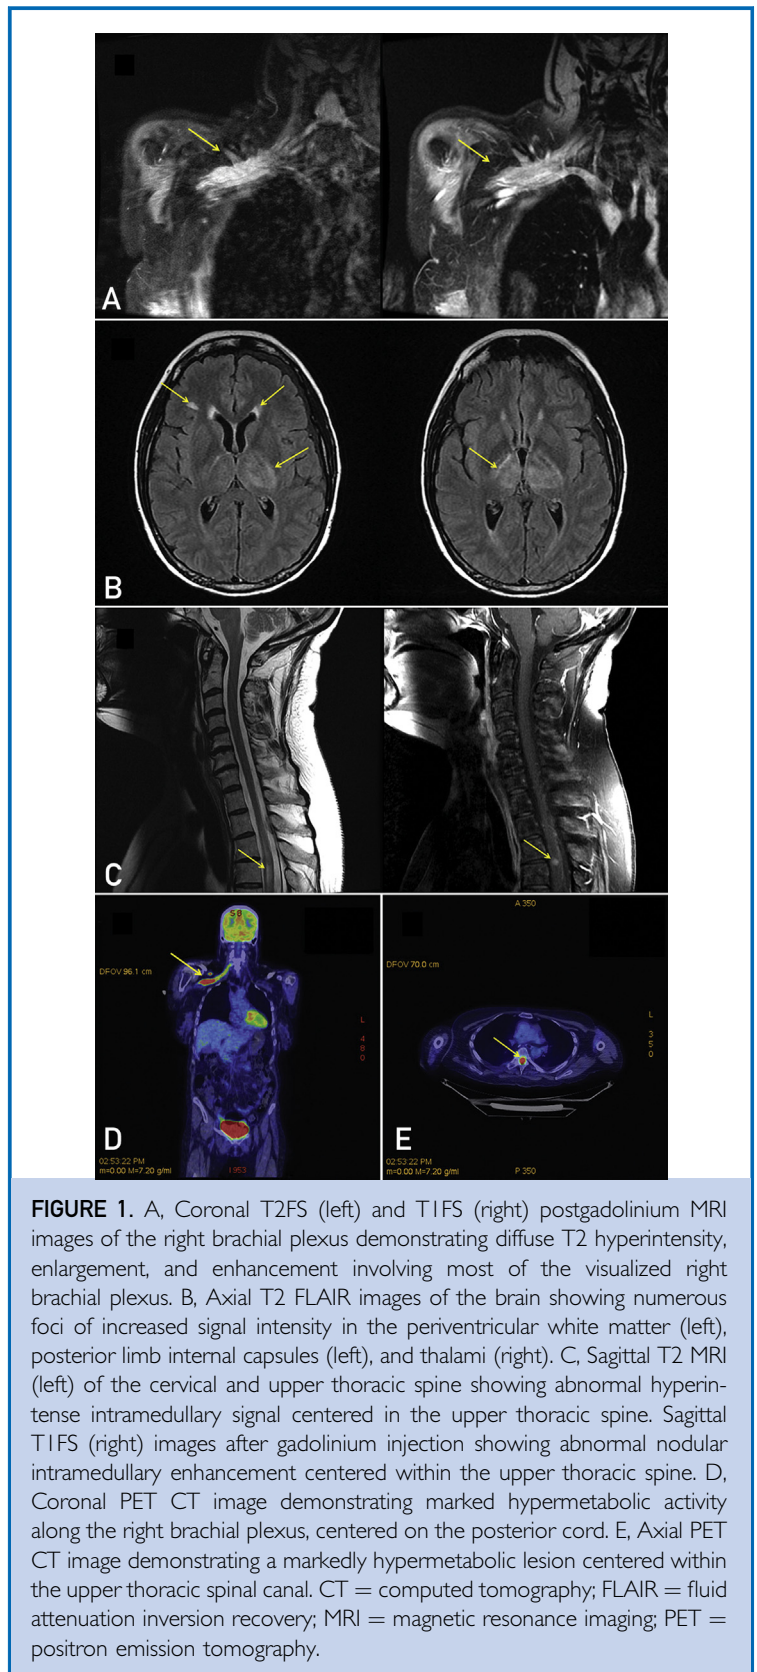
A, Coronal T2FS (left) and T1FS (right) postgadolinium MRI images of the right brachial plexus demonstrating diffuse T2 hyperintensity, enlargement, and enhancement involving most of the visualized right brachial plexus. B, Axial T2 FLAIR images of the brain showing numerous foci of increased signal intensity in the periventricular white matter (left), posterior limb internal capsules (left), and thalami (right). C, Sagittal T2 MRI (left) of the cervical and upper thoracic spine showing abnormal hyperintense intramedullary signal centered in the upper thoracic spine. Sagittal T1FS (right) images after gadolinium injection showing abnormal nodular intramedullary enhancement centered within the upper thoracic spine. D, Coronal PET CT image demonstrating marked hypermetabolic activity along the right brachial plexus, centered on the posterior cord. E, Axial PET CT image demonstrating a markedly hypermetabolic lesion centered within the upper thoracic spinal canal. CT = computed tomography; FLAIR = fluid attenuation inversion recovery; MRI = magnetic resonance imaging; PET = positron emission tomography.
